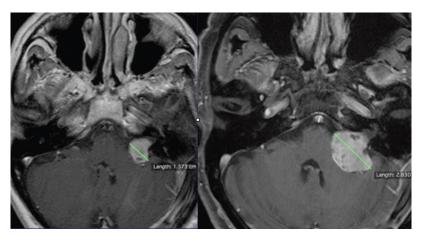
MRI showing fast growth (12.57 mm growth in 1 yr) in a patient on wait and scan.
